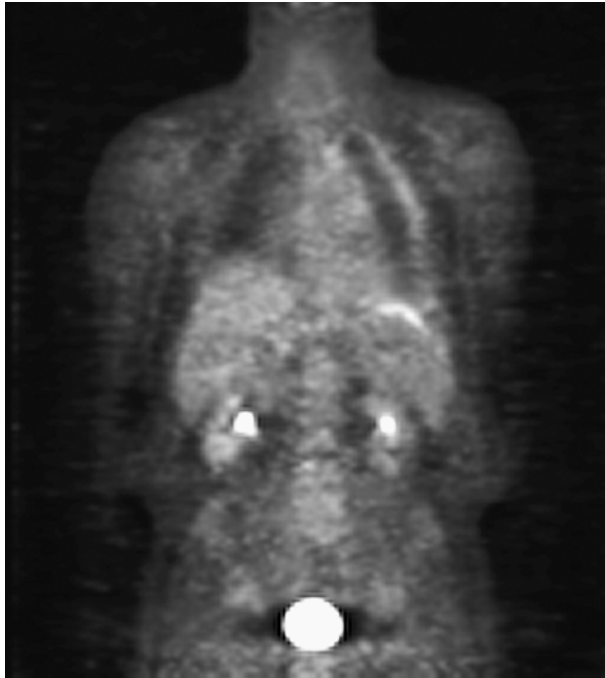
Positron emission tomography (PET) demonstrating a high standard uptake value (SUV) in a patient with a left-sided mesothelioma. Tumor involves all pleural and diaphragmatic surfaces.
